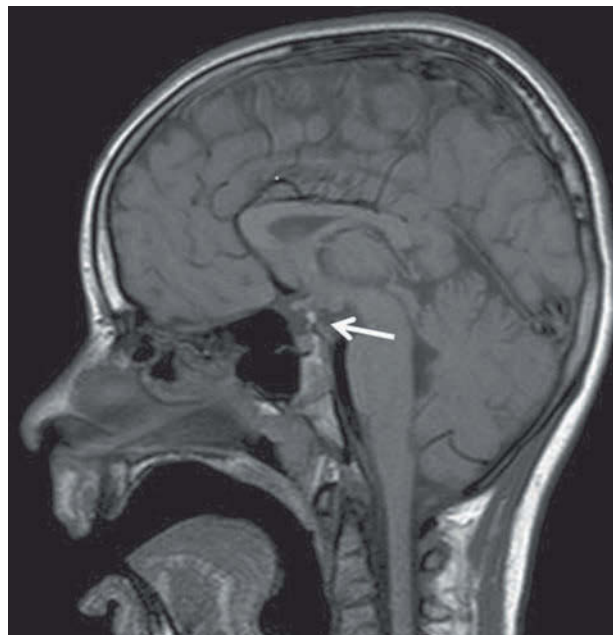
Sagittal MRI scan of the patient with *SOX3* duplication, showing pituitary hypoplasia, hypoplasia of the infundibulum, and an undescended/ectopic posterior pituitary. Note the hypogenesis of the corpus callosum.
